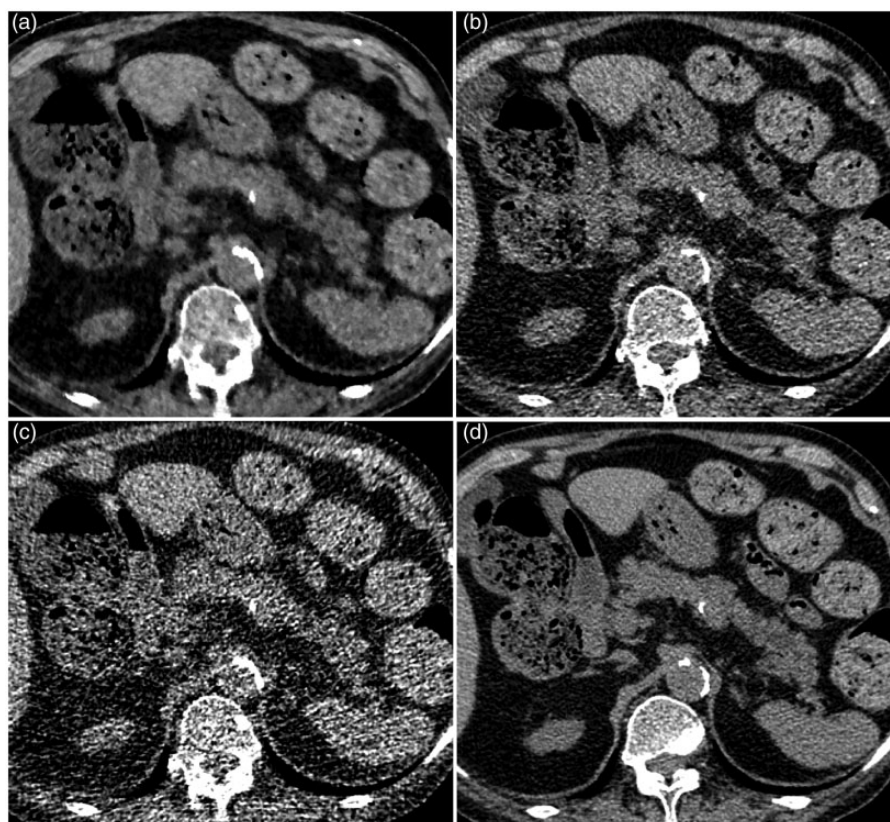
Axial unenhanced CT images of UL-MBIR (a), L-ASIR (b), UL-ASIR (c), and R-FBP (d) of an 81-year-old woman weighing 60 kg. A calcification of the splenic arterial wall is seen on R-FBP (d), but this patient has no pancreatic calcification. The evaluation score for this patient on UL-MBIR/L-ASIR/UL-ASIR was 2 (calcification probably not present)/2/2 by reader 1 and 4 (calcification probably present)/3 (calcification presence equivocal)/3 by reader 2. It is possible that a calcification of the splenic arterial wall has been misdiagnosed as pancreatic calcification on UL-MBIR (a) by reader 2.
